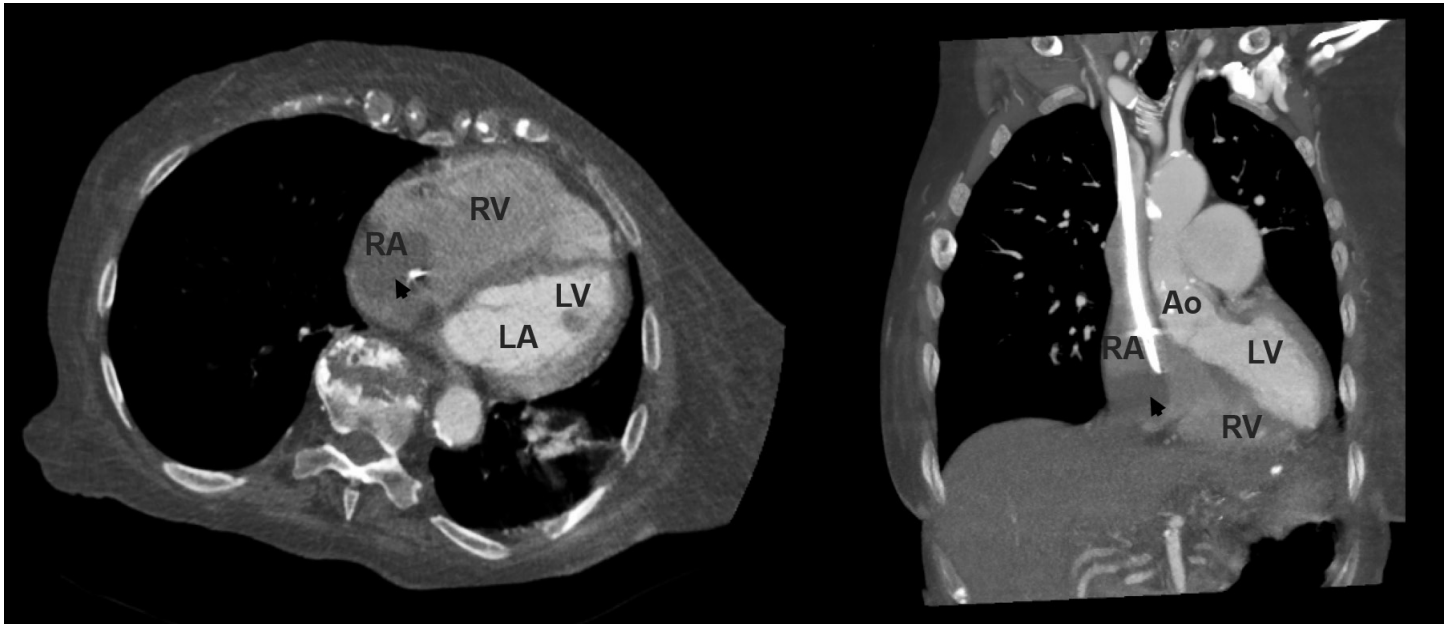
Computed tomography angiogram of the chest. Left (cross section) Right (coronal section). Right atrial mass is noted by the arrowhead. Dialysis catheter tip noted as a bright white artifact within the thrombus. LA, left atrium; RA, right atrium; LV, left ventricle; RV, right ventricle; Ao, aorta.
